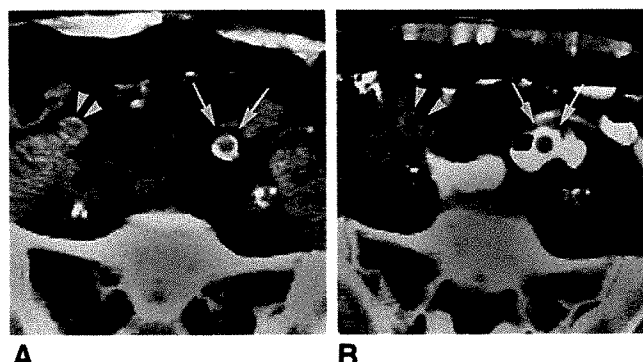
A and B, CT scans obtained before (A) and after (B) administration of rectal contrast material show intrasigmoidal course of left limit of aorta-bifurcation prosthesis (arrows). Arrowheads indicate right limit of graft.
